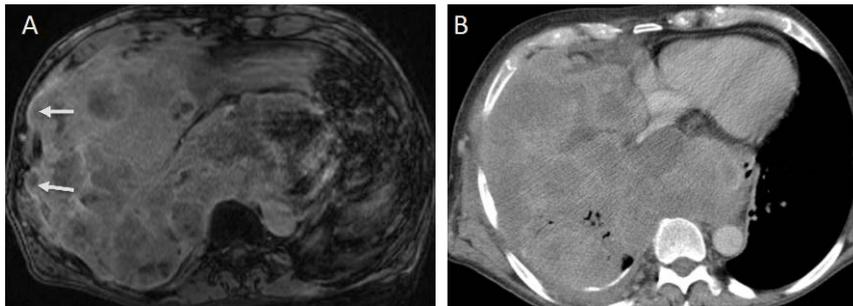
(A) Fat suppressed T1-weighted MRI and (B) CT in 49-year-old with malignant mesothelioma of the right hemithorax.
